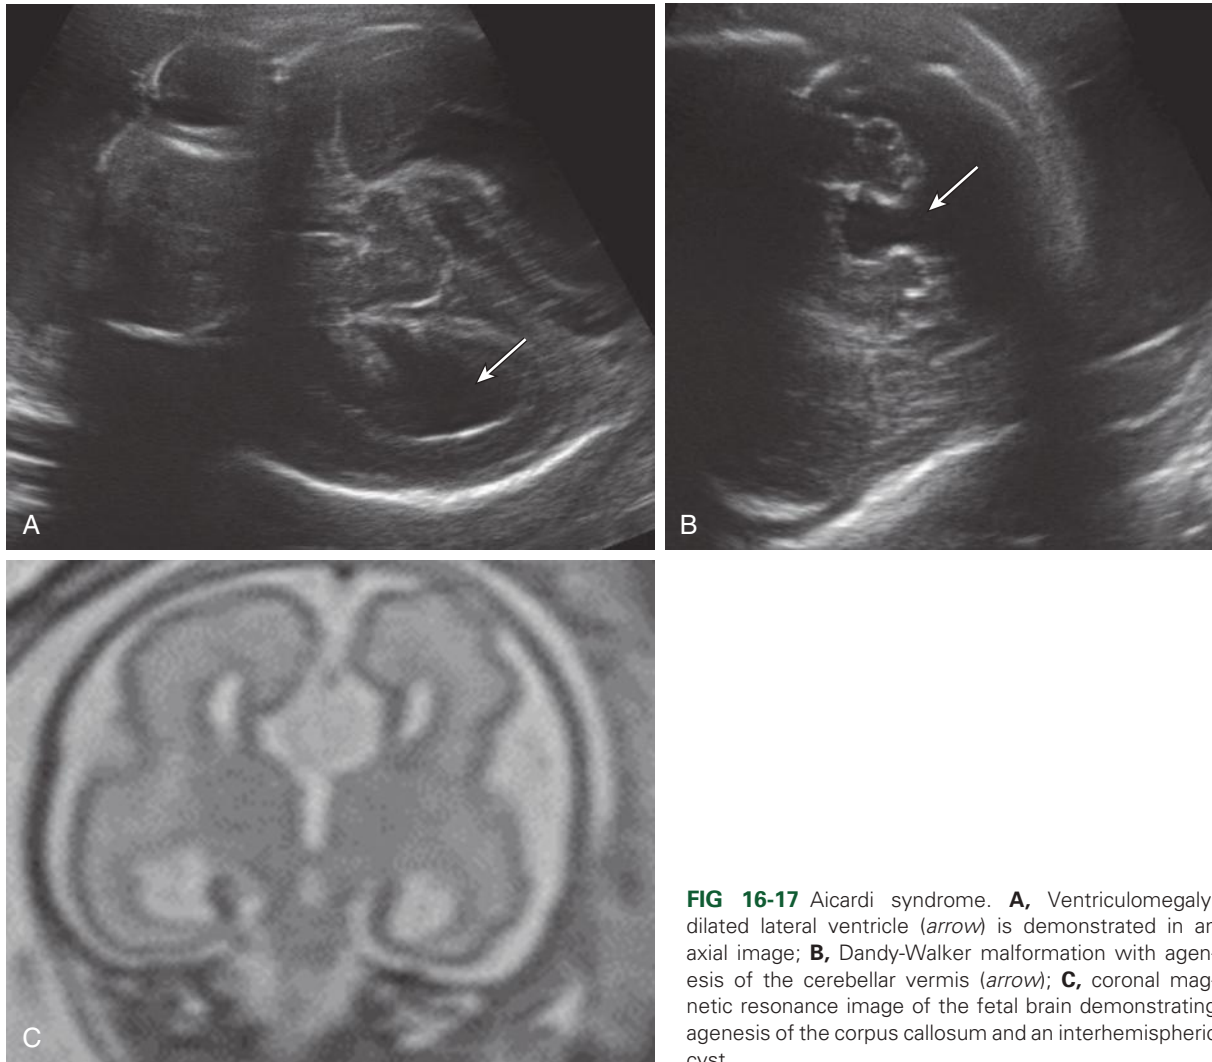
Aicardi syndrome. A, Ventriculomegaly; dilated lateral ventricle (*arrow*) is demonstrated in an axial image; B, Dandy-Walker malformation with agenesis of the cerebellar vermis (*arrow*); C, coronal magnetic resonance image of the fetal brain demonstrating agenesis of the corpus callosum and an interhemispheric cyst.
